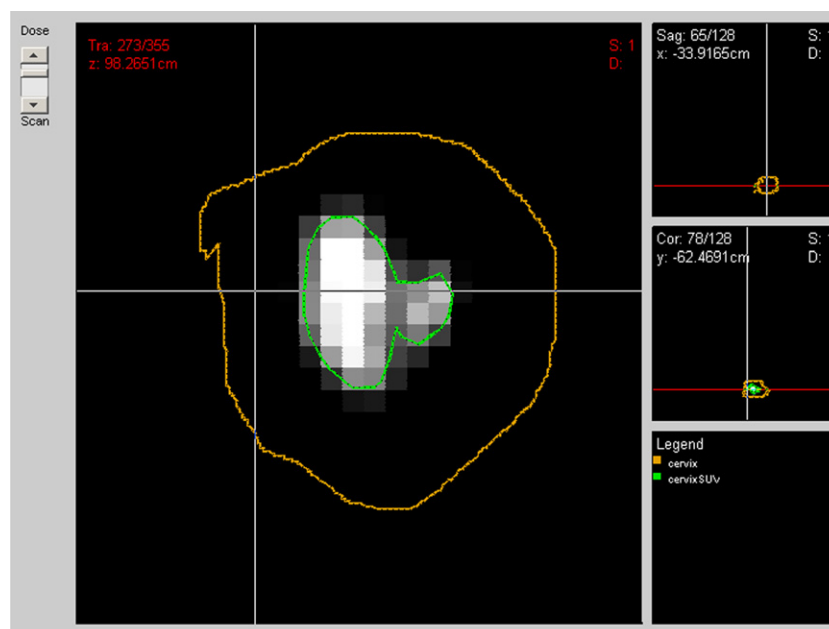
A pre-treatment PET scan of a cervix cancer case of a patient with persistent tumor at 3 months follow-up post-radiotherapy treatment. The cervix clinical tumor volume (CTV) (brown) and the 40% maximum SUV delineated gross tumor volume (GTV) (green) were outlined by the physician.
